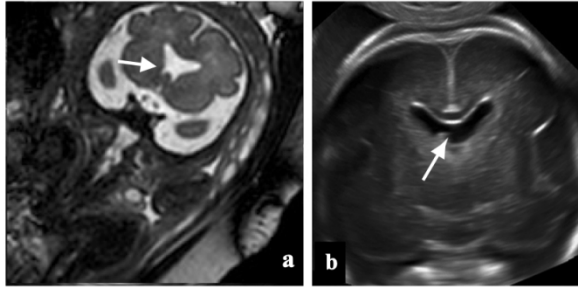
Complete agenesis of septum pellucidum (ASP) at antenatal Magnetic Resonance Imaging (a) and Ultrasound (b)
